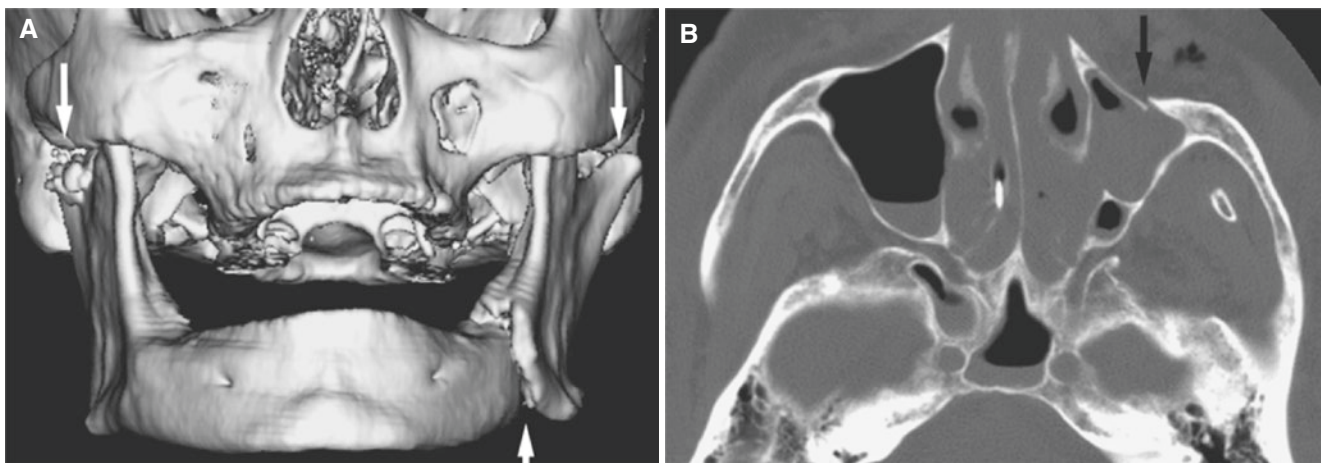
Mandibular bilateral neck, mandibular body and maxillary sinus wall fractures; 58-year-old female who was struck by a car with loss of consciousness. (A) 3D CT image shows fracture of left
